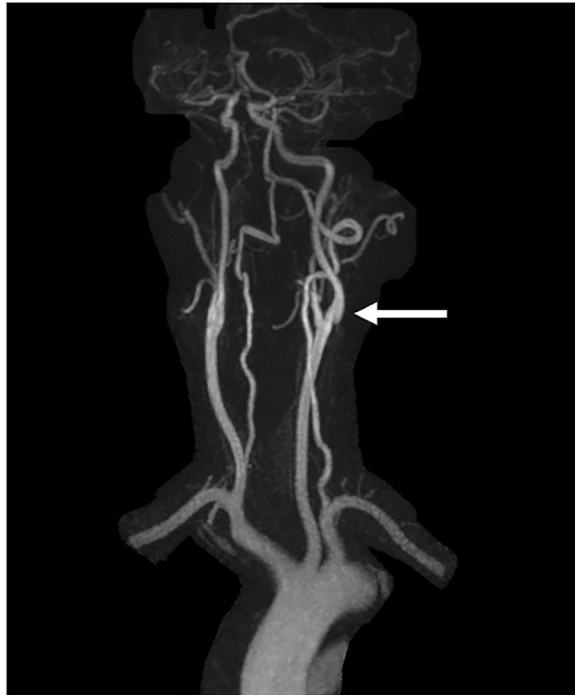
Magnetic resonance imaging of a 77-year-old female patient. White arrow points to a film-like structure in the posterior bulb protruding into the vessel lumen, corresponding to a carotid web.
